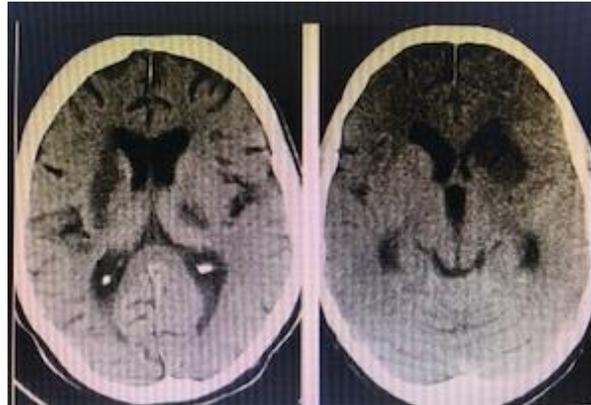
CT scan of patient showing a hypo density in his left hemisphere
